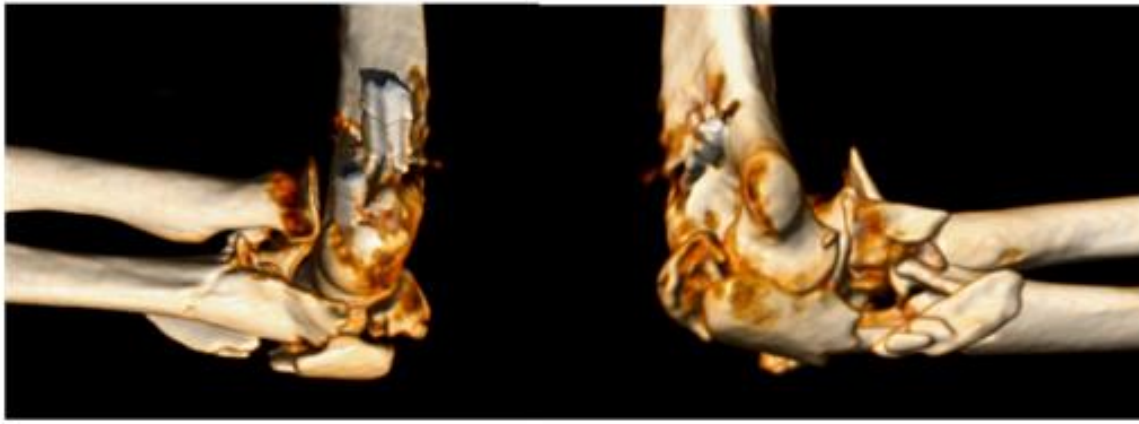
Case 2 - 3D reconstruction from CT
